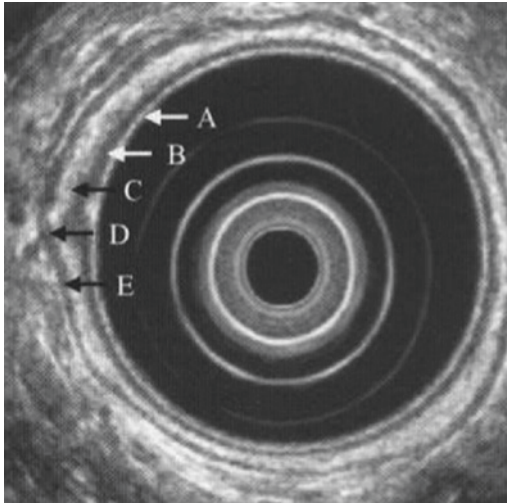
Endoscopic ultrasound of the esophagus with five distinct layers: A) mucosa, B) muscularis mucosae, C) submucosa, D) muscularis propria, and E) adventitia
